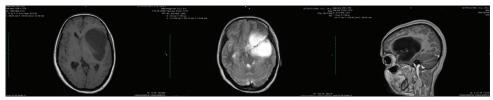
Axial T1-weighted (T1W), T2-weighted (T2W) and sagittal T1W postcontrast low grade glioma. A well-defined left frontotemporal homogenously enhancing T1W and T2W cystic lesion with no enhancement on T1W sagittal section
